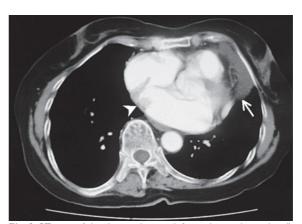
CT scan of the thorax shows a left atrial mass (arrowhead) and a probable pericardial cyst (arrow).
